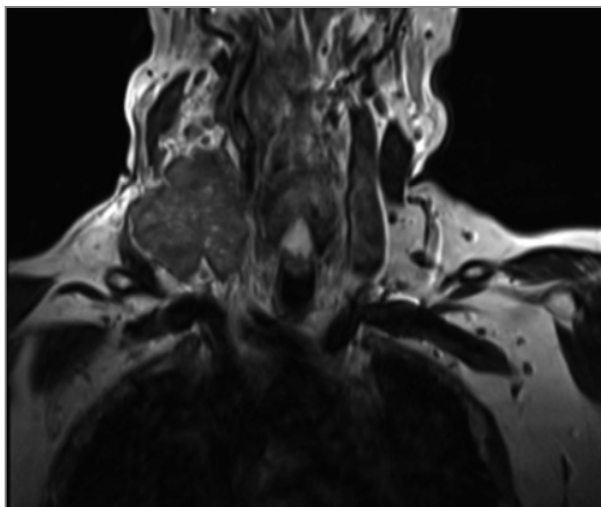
Coronal MRI (T2-weighted) of neck with dominant cervical lymphadenopathy
